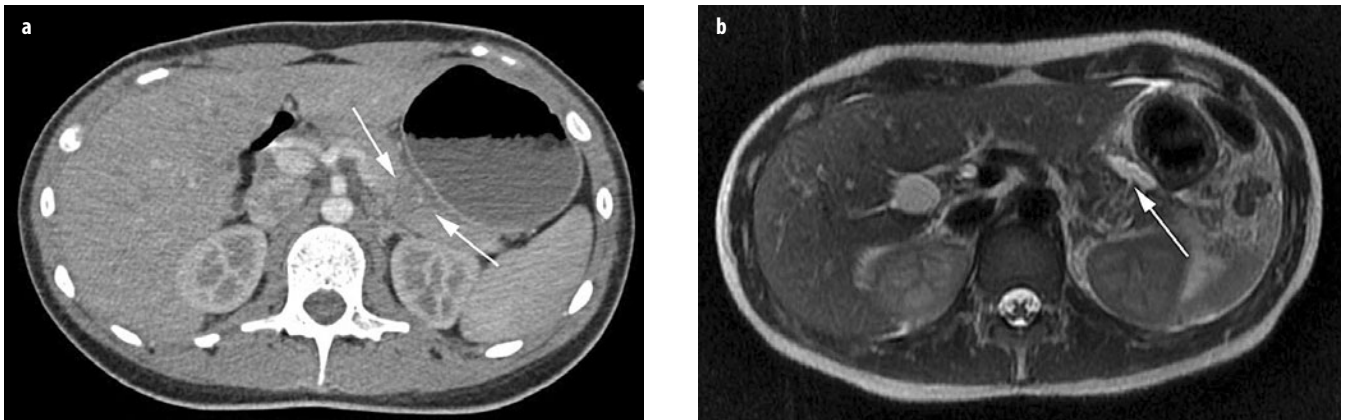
a, b. A 21-year-old female patient after blunt abdominal trauma showing a deep (>50% of parenchymal thickness) transection (*arrows*) of the pancreas on computed tomography (CT). b Suspected main pancreatic duct injury was confirmed on T2-weighted magnetic resonance (MR) imaging, demonstrating the fracture line of the pancreas and a peripancreatic fluid collection (*arrow*)
